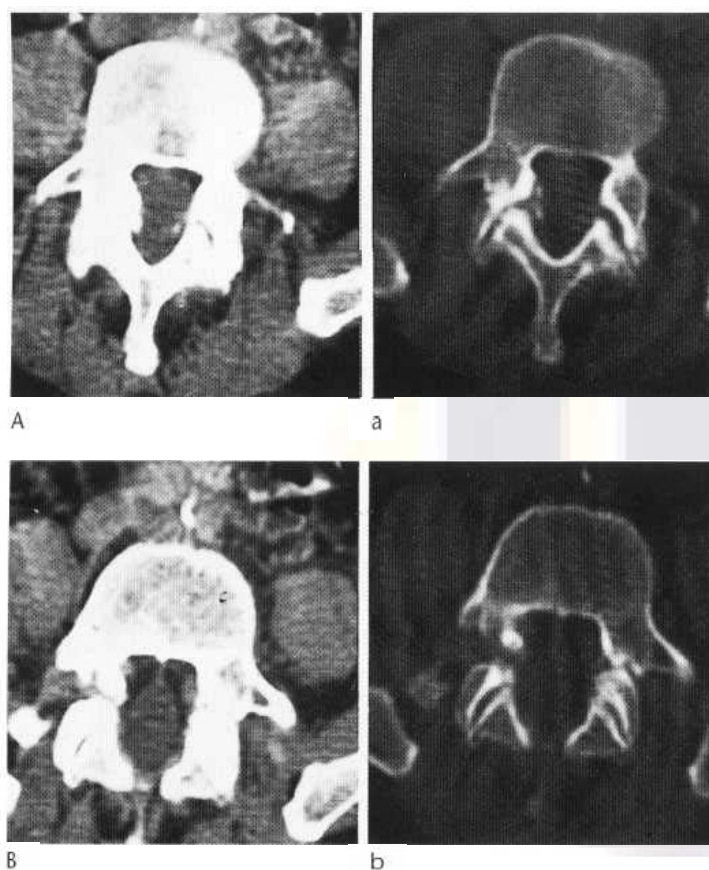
Spondylolisthesis of the fourth lumbar vertebra at CT. (A,a) At the level of the pedicles and superior articular facets. (B,b) Through fractured pars intra-articularis. Images are made at window setting appropriate to show both soft tissue and bone. Note that the forward slip of the body of L4 has elongated the sagittal diameter of the spinal canal; there is no nerve root compression.
